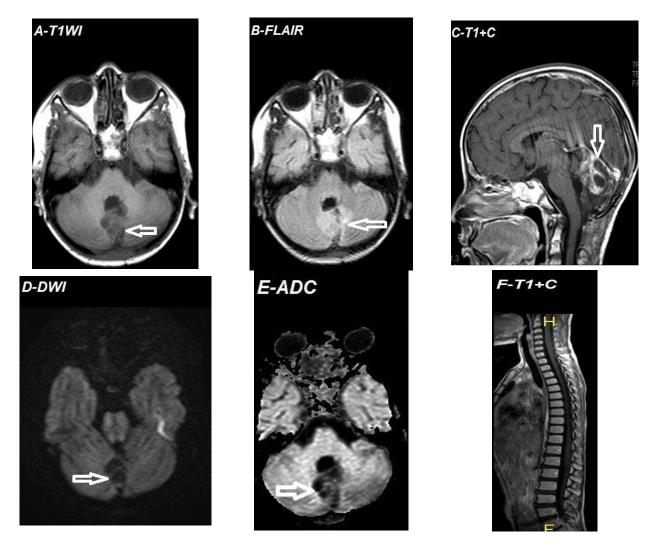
(Error! No text of specified style in document.1): Recurrent medulloblastoma (A) Axial T1WI hypointense SOL in the vermis encroaching into the 4th ventricle (B) Axial FLAIR showing the lesion is hyperintense (C) Sagittal T1 post-contrast image showing the lesion is heterogeneously enhanced with areas of cystic degeneration (D &E) DWI and ADC map showing the lesion facilitated in diffusion (F) Sagittal T1 post contrast image showing normal spine.
